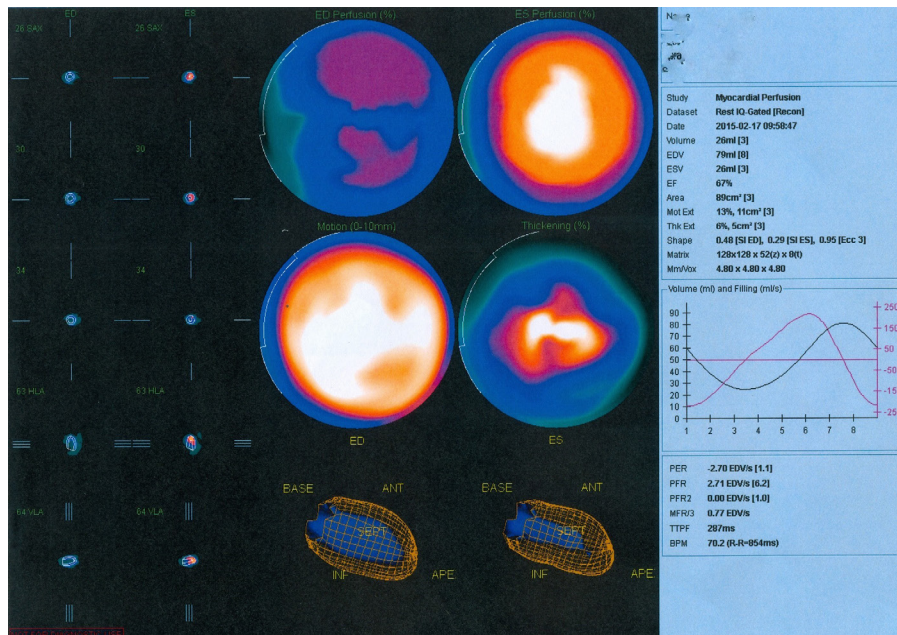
A resting C-SPECT scan of a female patient aged 69 who presented with chest pain and intact coronary arteries (class II effort angina)
